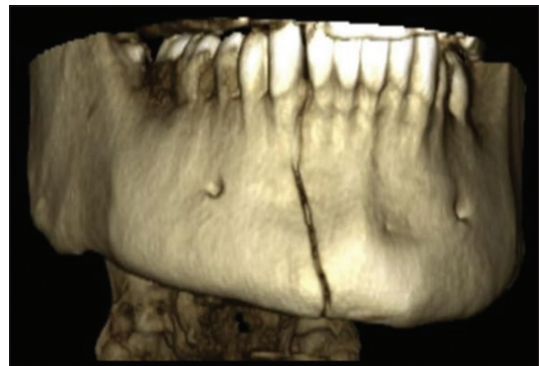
Three-dimensional-computed tomography reconstruction image showing right parasymphyseal fracture with mandible involving the inferior border
